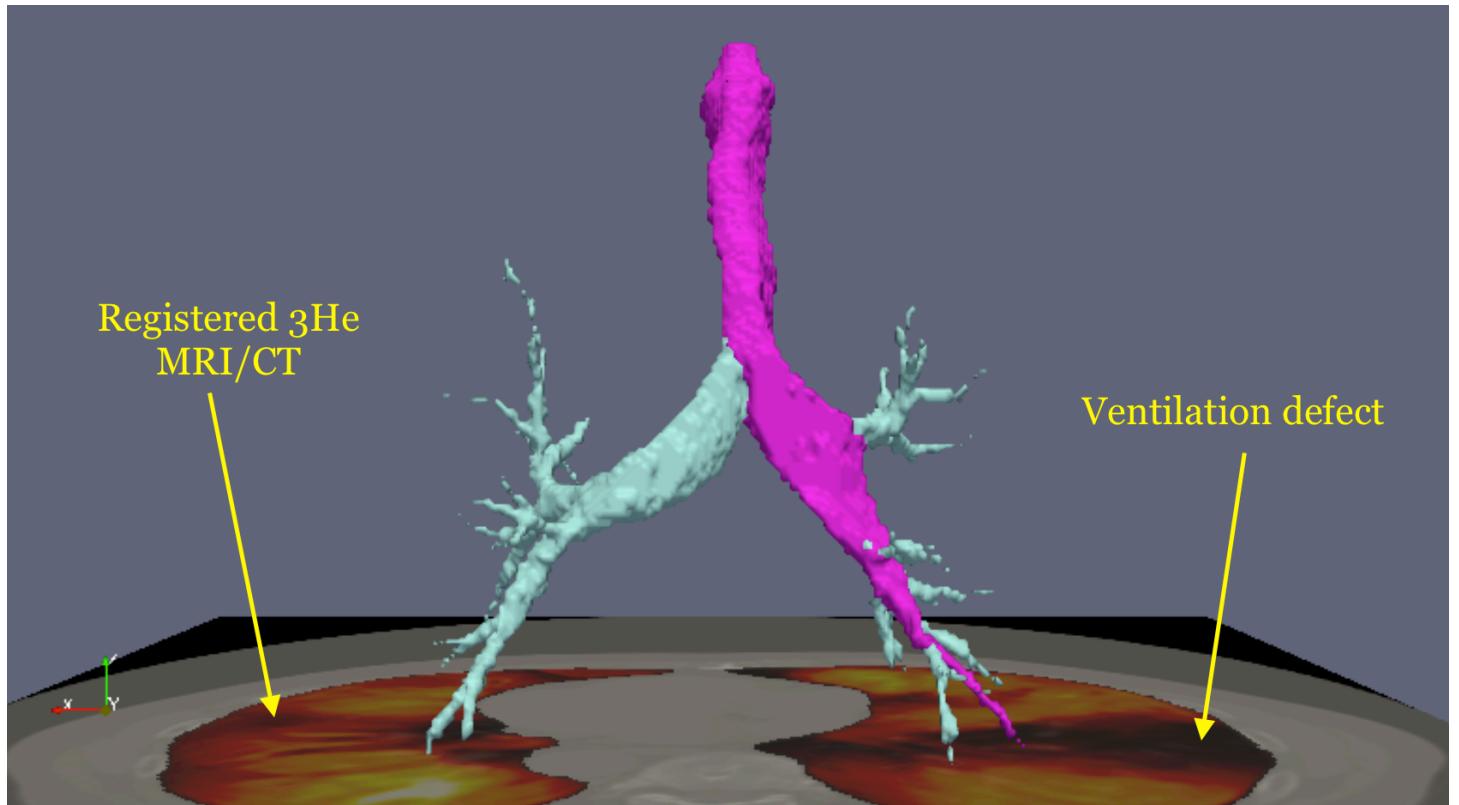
Potential clinical use case for identifying the feeding airway branch path to the ventilation defect. The functional ventilation image is normalized to the corresponding CT image. The airways are segmented in the individual subject space. After identification of the ventilation defect of interest, we can automatically determine the bronchiole pathway from the trachea to the defect.
